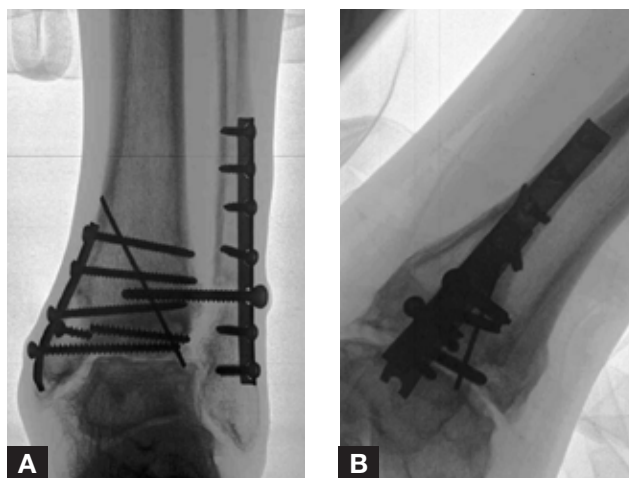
Anteroposterior (A) and lateral (B) radiographs 66 months after surgery show slightly narrowed but well-maintained tibiotalar joint space and evidence of anterior tibial spurring. American Orthopaedic Foot and Ankle Society score was 98.
